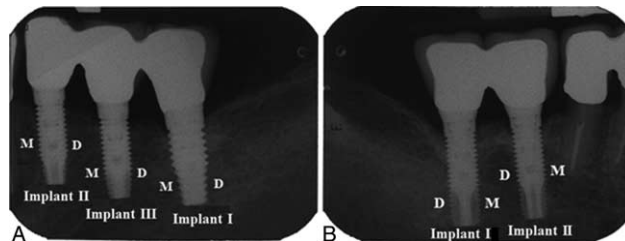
Implant marking. Representative X-ray photographs of a 3-implant-supported FPP (A) and a 2-implant-supporting FPP (B). M = mesial, D = distal.
